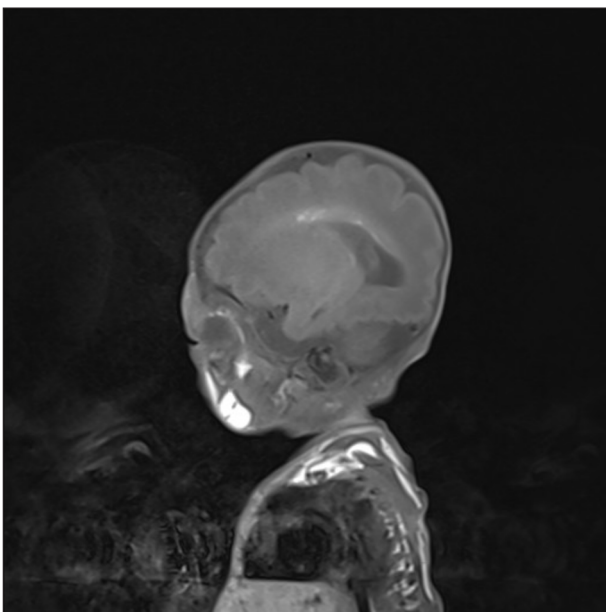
Brain MRI showed brain abnormalities.
